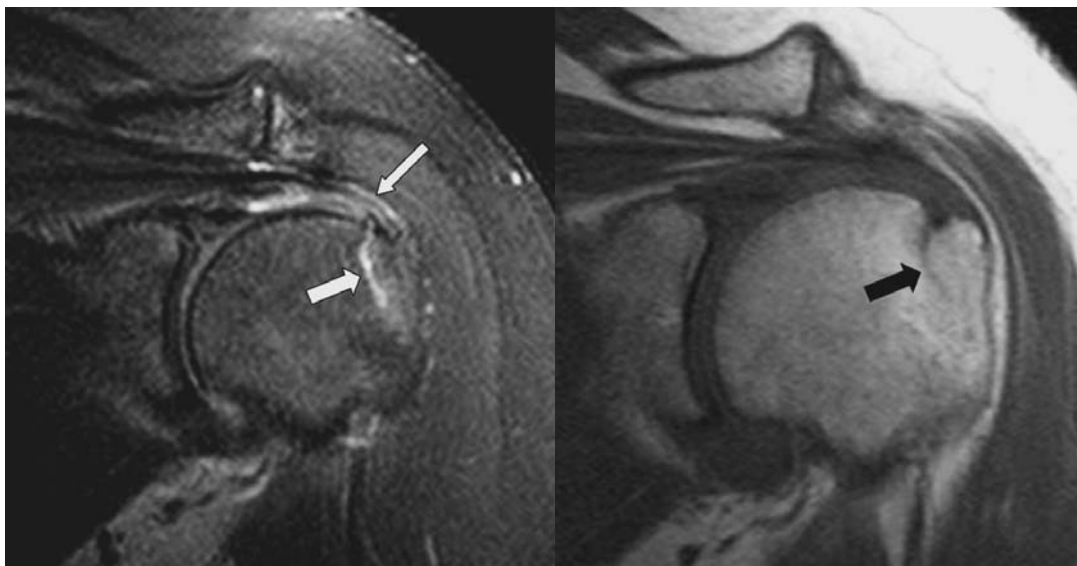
Occult avulsion injury of the greater tuberosity. Oblique coronal fat suppressed T2 weighted MR image (left) shows the fracture line (thick arrow) with partial healing caudally. There is also a partial tear of the supraspinatus tendon (thin arrow). The oblique coronal T2 weighted MR image (right) shows the fracture line (black arrow) and normal marrow in the most caudal part of the lesion
